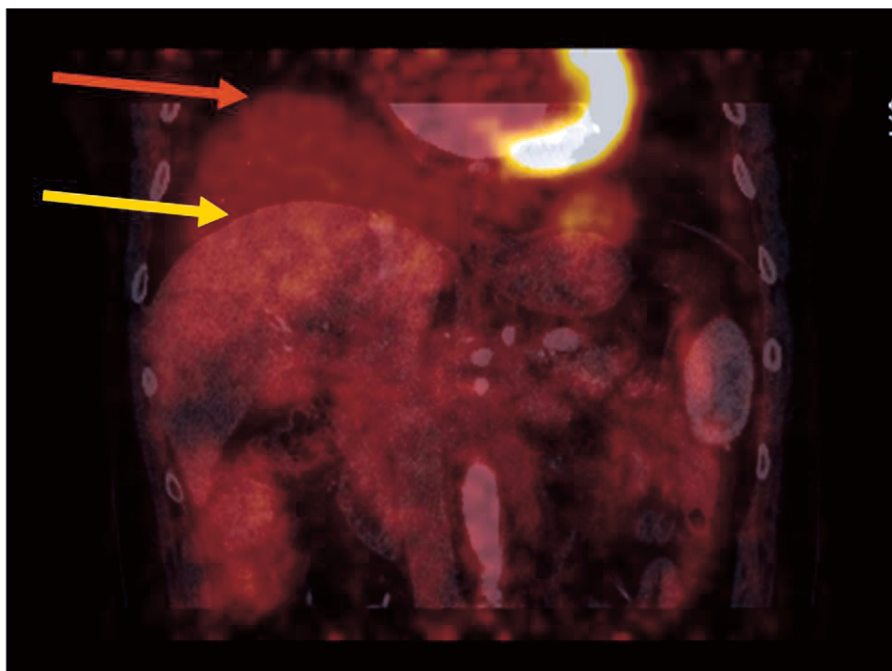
FDG PET/CT with contrast-enhanced CT: misregistration between contrast-enhanced CT performed during deep inspiratory breath-hold and PET images acquired during normal breathing. Red arrow indicates upper liver surface on PET and yellow arrow indicates liver surface on CT. Misregistration may result in serious image misinterpretation.
